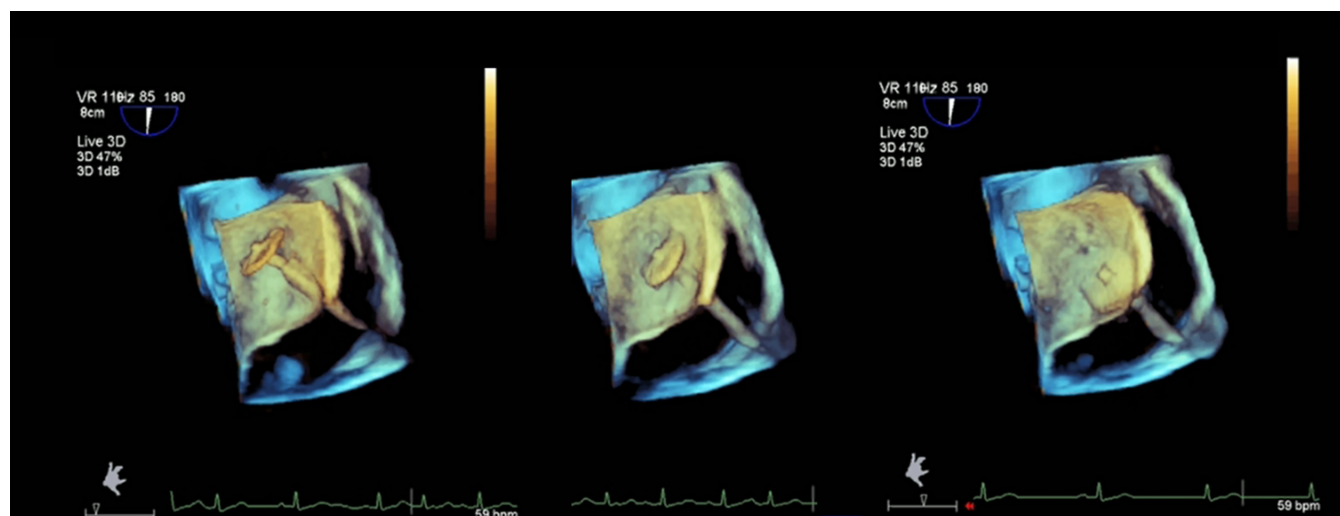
3D Transesophageal echocardiography images from PFO device closure guidance during positioning step
